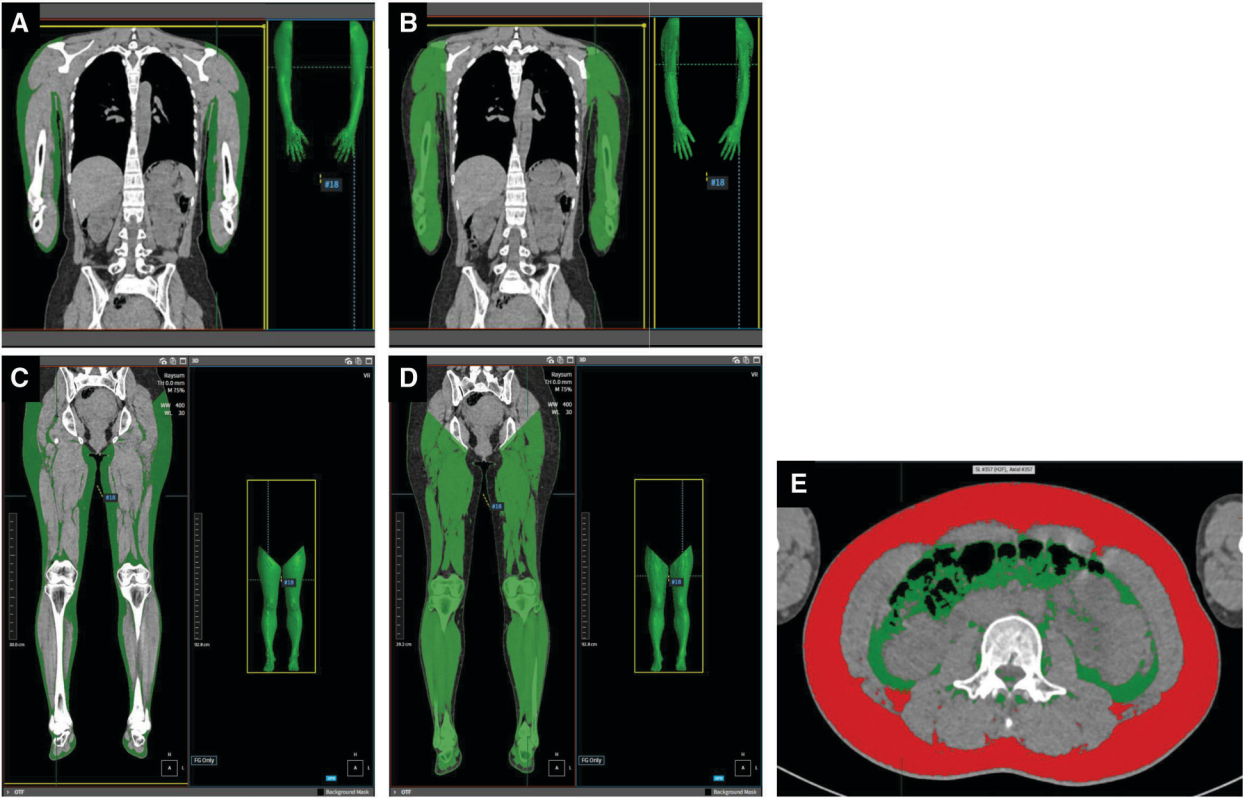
Example of body composition analysis using low-dose whole-body CT. (A-D) CT image segmentation was performed using 3D software to analyse fat tissues (A, C) and fat-free tissues (B, D) in both the upper and lower extremities. (E) In axial abdominal CT images, adipose tissue was manually segmented into subcutaneous fat (red) and VAT (green), and their respective amounts were measured. The sum of these 2 was defined as the segmental abdominal FM.
